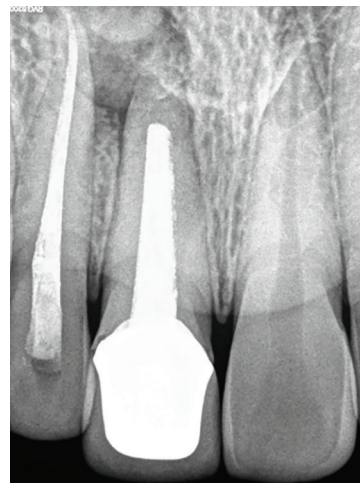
One-year follow-up radiograph shows the lesion was completely healed
